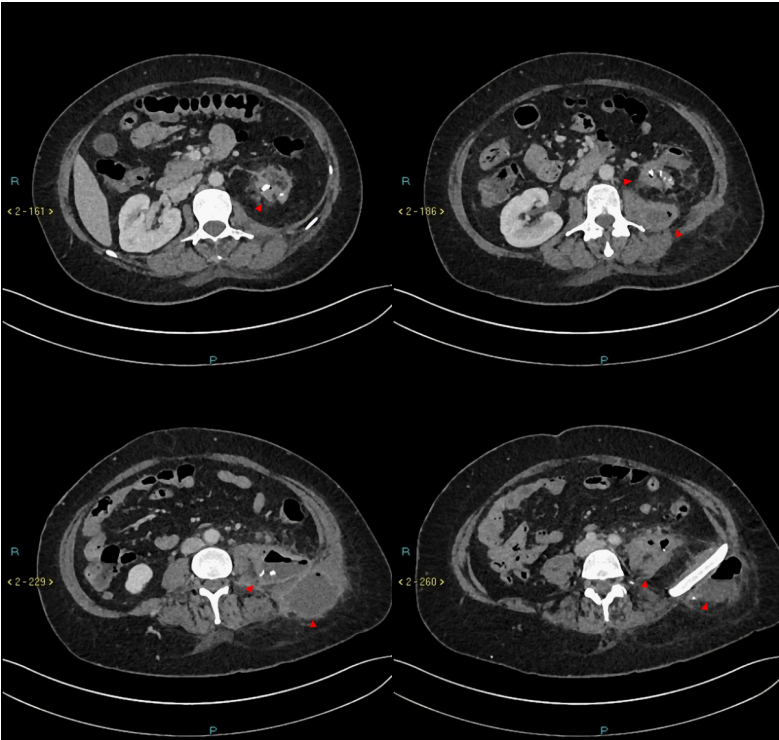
CT Scan performed on admission. Multiple axial sections at the levels L1-4 showing an abnormal left kidney with calculi and associated collection extending into and beyond psoas muscle into subcutaneous tissues.
